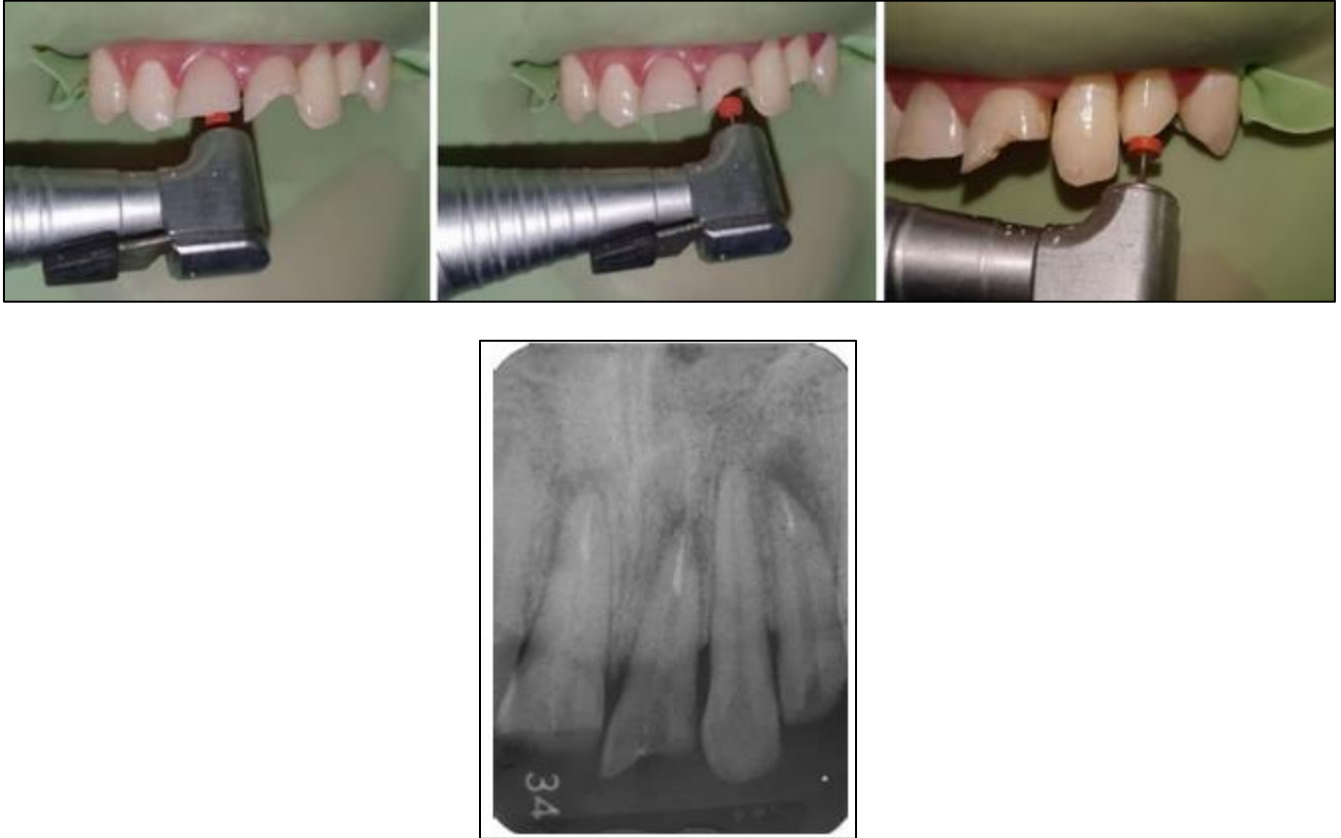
Reduction of gutta-percha points in teeth 11, 21, and 22(2) was confirmed by radiographic examination (RO)
